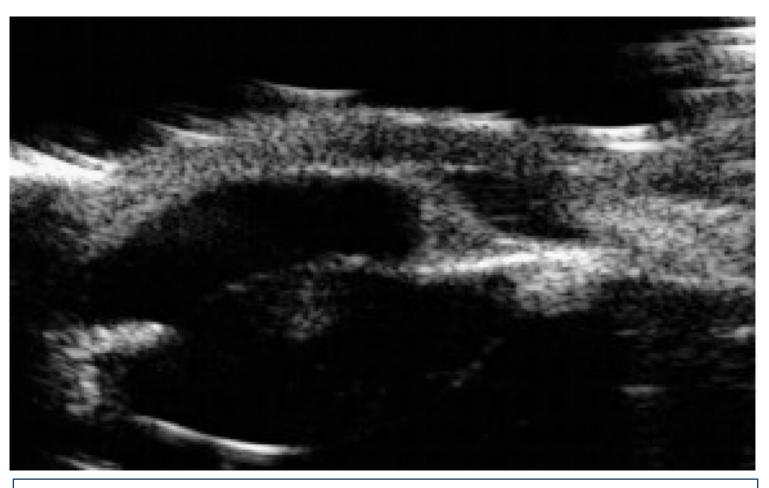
Anterior segment B-Scan ultrasound OS at age 4 days with anterior synechiae from iris to cornea with anterior lens opacity underlying corneal opacity
